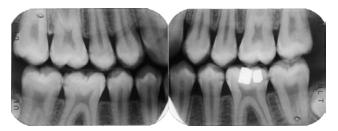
(radiographs © of Dr Louis Mackenzie)
